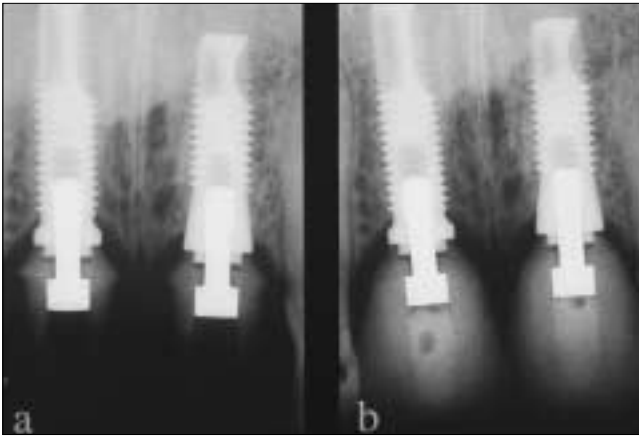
Periapical radiographs: a) 11 and 21: implants/posts, b) 11 and 21: implants/abutments ceramic crowns cemented.
